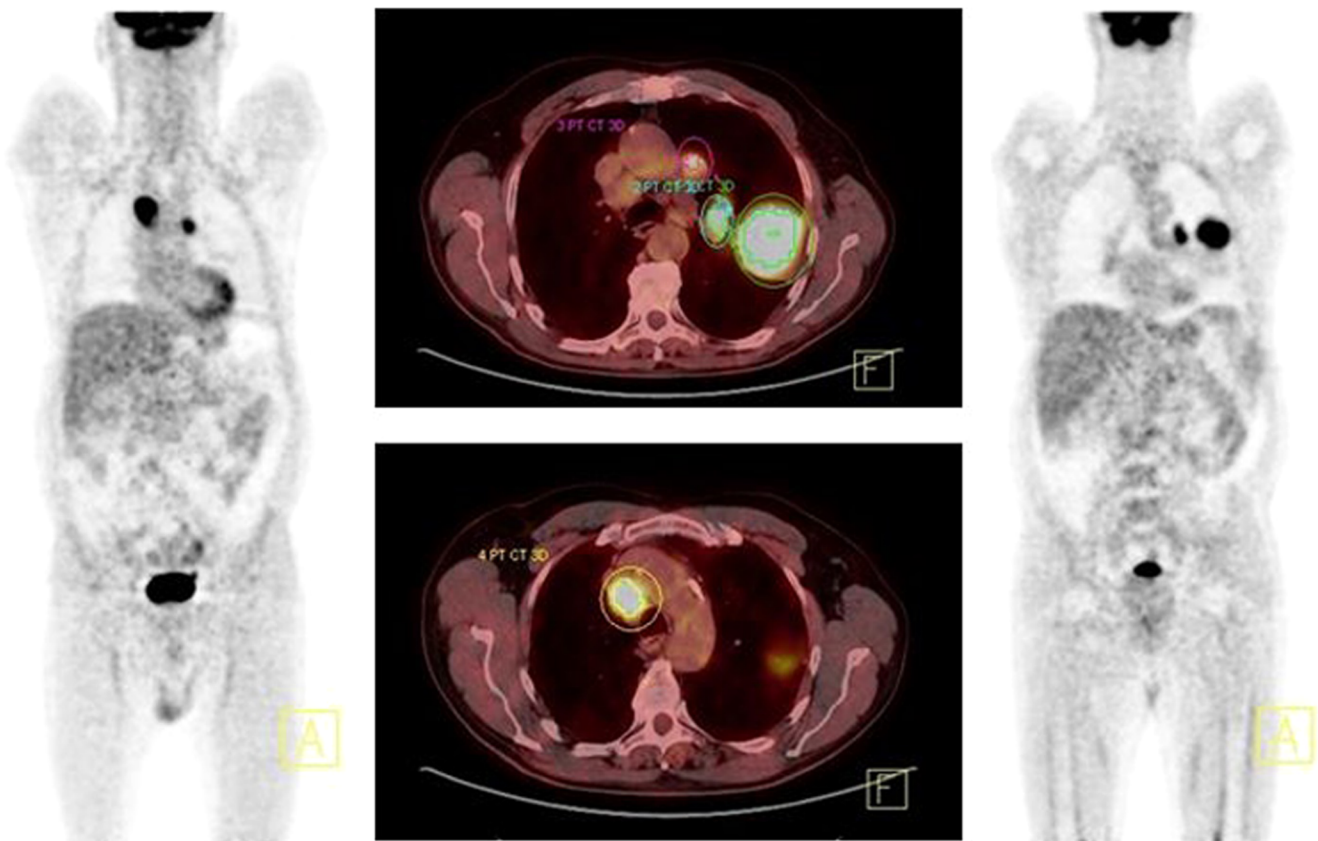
Regions of interest on PET/CT images for the MTV and TLG computations on a patient
